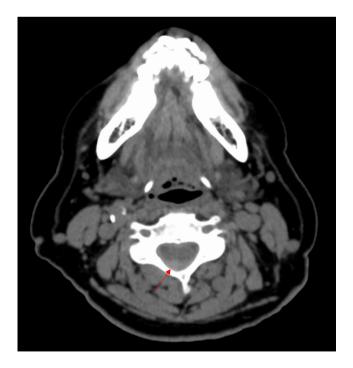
Axial cervical computed tomography indicating a heterogeneous high-density mass in the epidural cavity posterior to the spine (red arrow).
